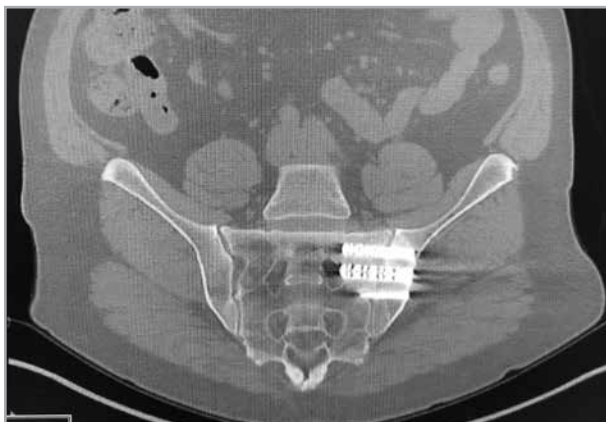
Coronal computed tomography image indicating SIJ fusion hardware impinging into the S1 neural foramen.
